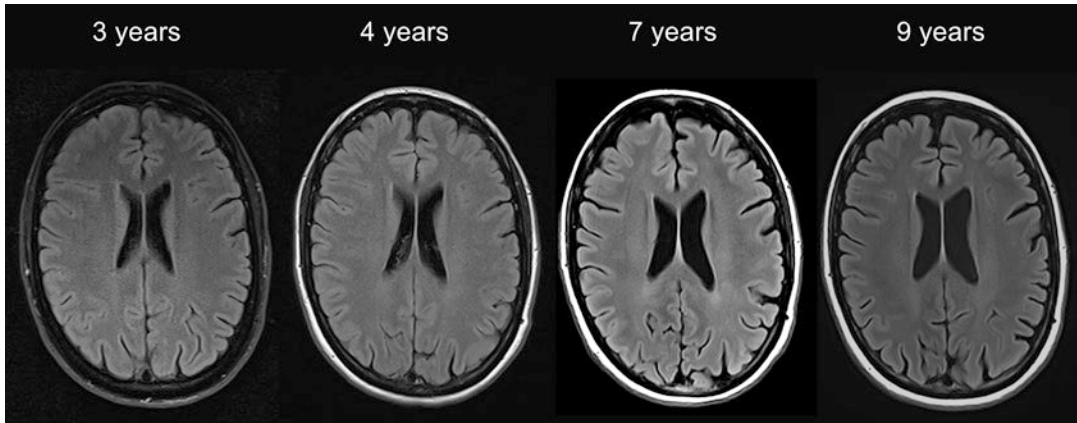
Neuroimaging characteristics (brain MRI, axial sections) of a *C9orf72* patient with a slow progression evocative of FTD phenocopy. Follow-up over a 9-year disease duration
